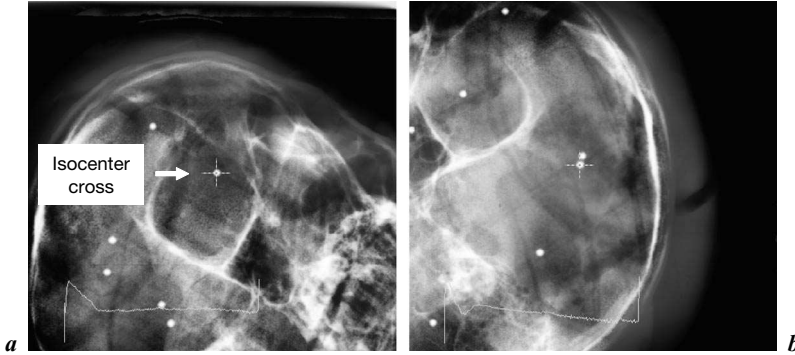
Two verification X-ray images for evaluation of deviation between the X-ray isocenter (cross) and the planned isocenter (center of the metal sphere). The cross mark (arrow) at the center of image represents the isocenter position of the X-ray system.
